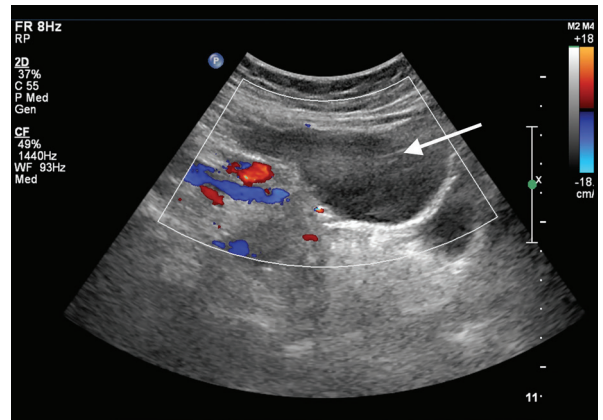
Abdominal ultrasound demonstrates a dilated fluid-filled structure in continuity with the caecal pole, in keeping with an appendix mucocoele.
